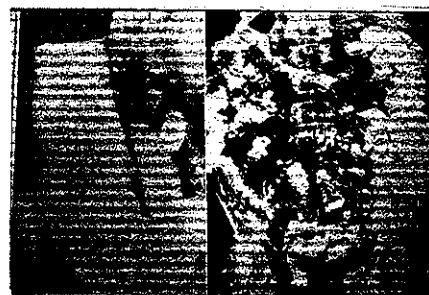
X-ray of a dilated stomach, left; X-ray of small intestines, right
